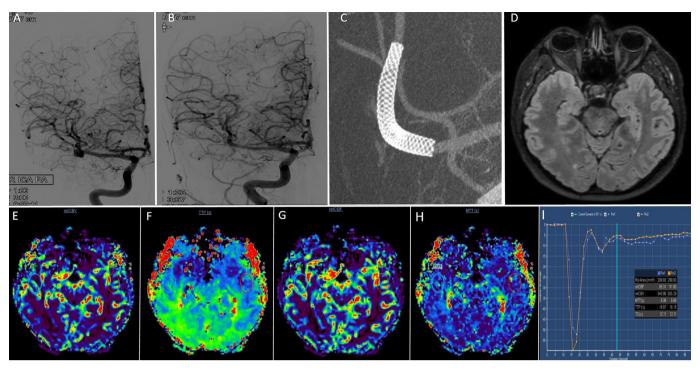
Patient 16. Digital subtraction angiography (DSA) with anterior—posterior view (A) showing a saccular aneurysm of the right middle cerebral artery (MCA) bifurcation. Five-year follow-up DSA with anterior—posterior view (B) and flat detector computed tomography angiography (FDCTA) image (C) demonstrating the complete occlusion of the aneurysm with the luminal patency of the stent, which extends from the MCA M1 segment to the proximal MCA M2 segment superior trunk. Axial fluid-attenuated inversion recovery (FLAIR) image (D) revealing the absence of any ischemic lesion related to the territory associated with the MCA inferior trunk that was jailed following flow diversion. Relative cerebral blood volume (rCBV) (E), relative cerebral blood flow (rCBF) (F), mean transit time (MTT) (G), time-to-peak (TTP) (H) maps and measurement results (I) are shown on dynamic susceptibility contrast (DSC) magnetic resonance perfusion images. An increase in TTP and MTT and a decrease in rCBF are observed in the jailed right MCA inferior trunk territory.
